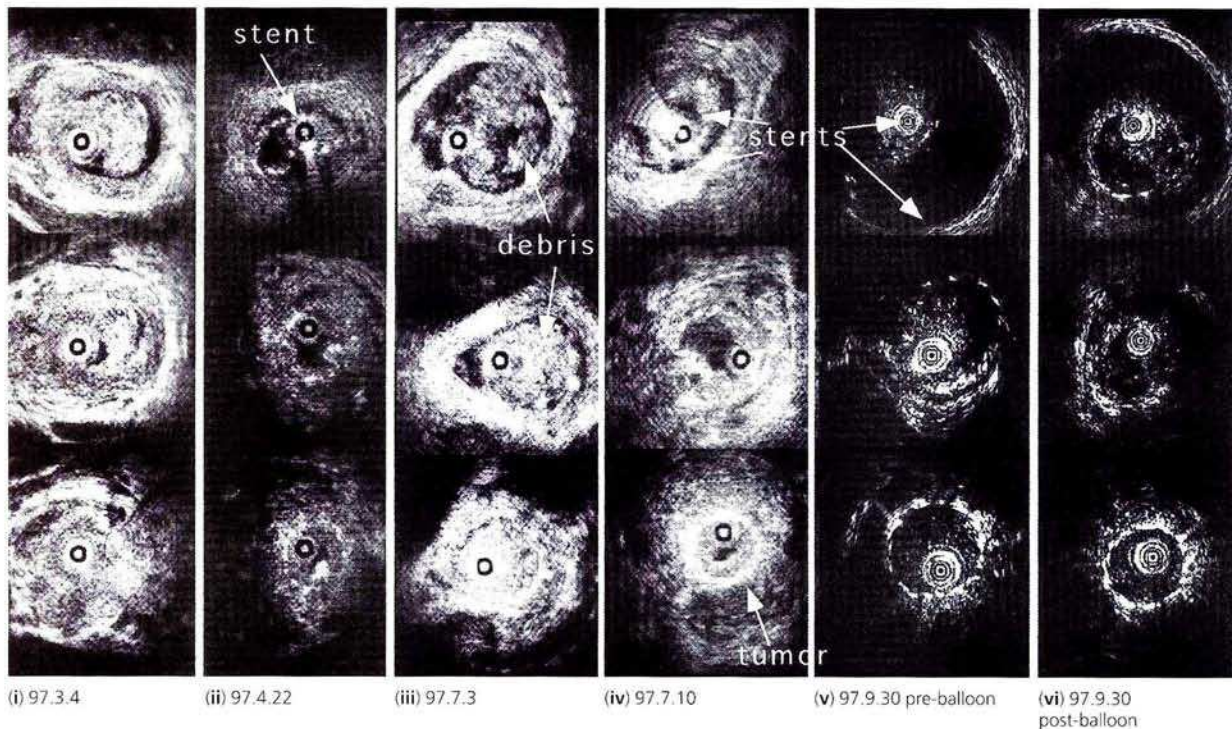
Intraductal sonography (IDUS) findings from the same patient on: (i) 4 March, (ii) 22 April, (iii) 3 July, (iv) 10 July, (v) 30 September (before biliary washing using balloon catheters), (vi) 30 September (after biliary washing using balloon catheters). (All dates in 1997).
